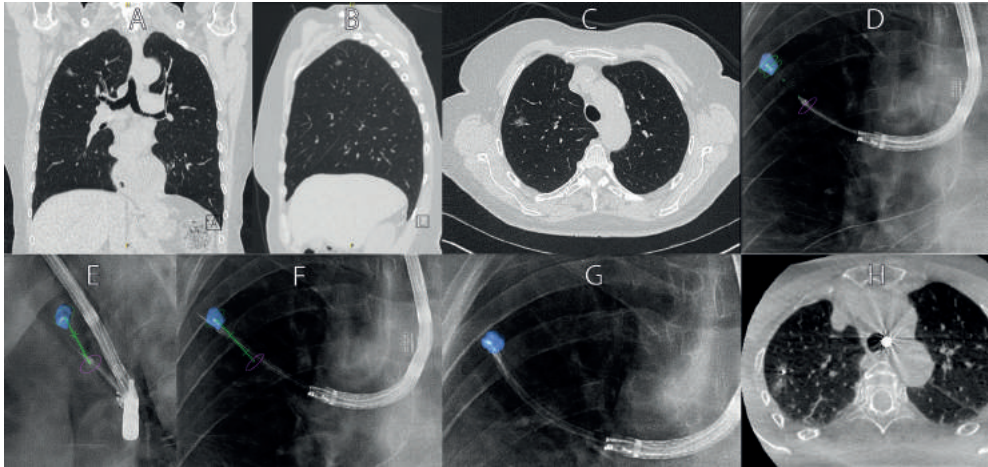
Case example of CBCT and augmented fluoroscopy based navigation.
